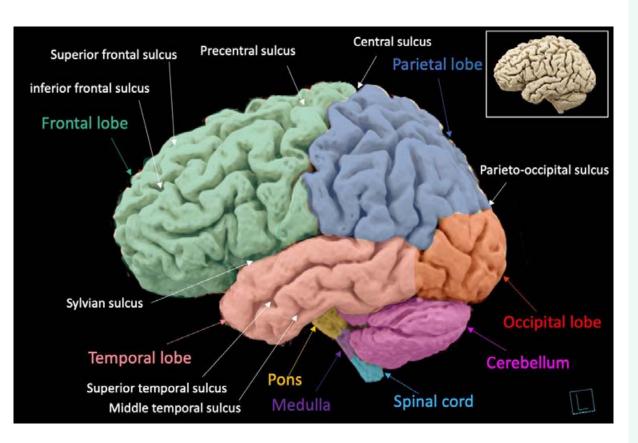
Annotated human brain surface rendering reconstruction from a 3D MRI acquisition. Lateral view. Courtesy Minerva Becker, MD and Jorge Remuinan, Geneva University Hospitals.
